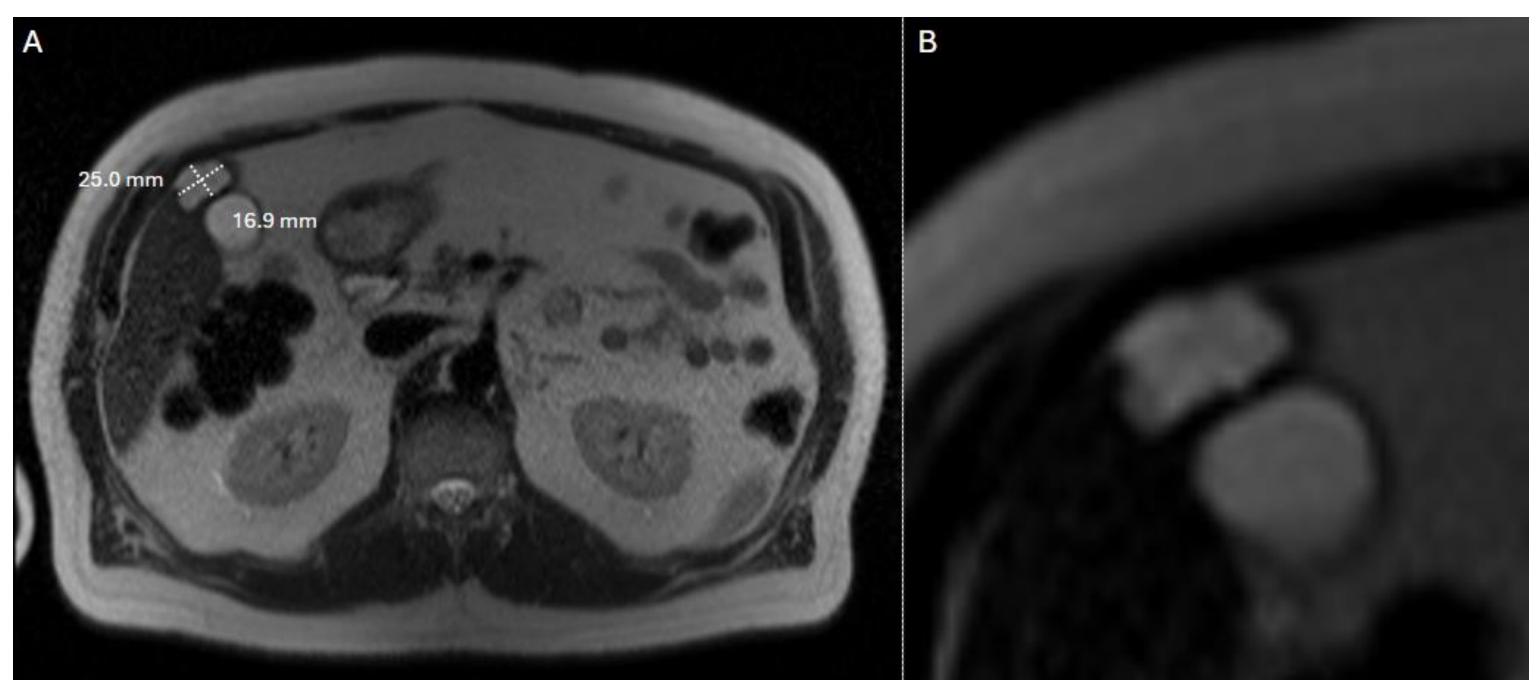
(A) Pre-procedural MR image demonstrating stable lobulated cystic lesion with multiple internal septation in segment 4B, measuring approximately 2.5 x 1.7 cm on T2 without evidence of enhancement or diffusion restriction, consistent with biliary cystadenoma. (B) Magnified MR image further shows multiple internal septations and lobulated appearance.
